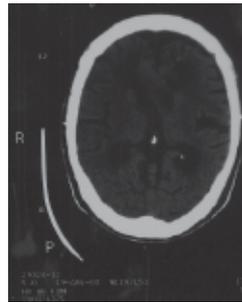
Computed tomograph showing a radiographic assessment at 3 days postoperatively.
